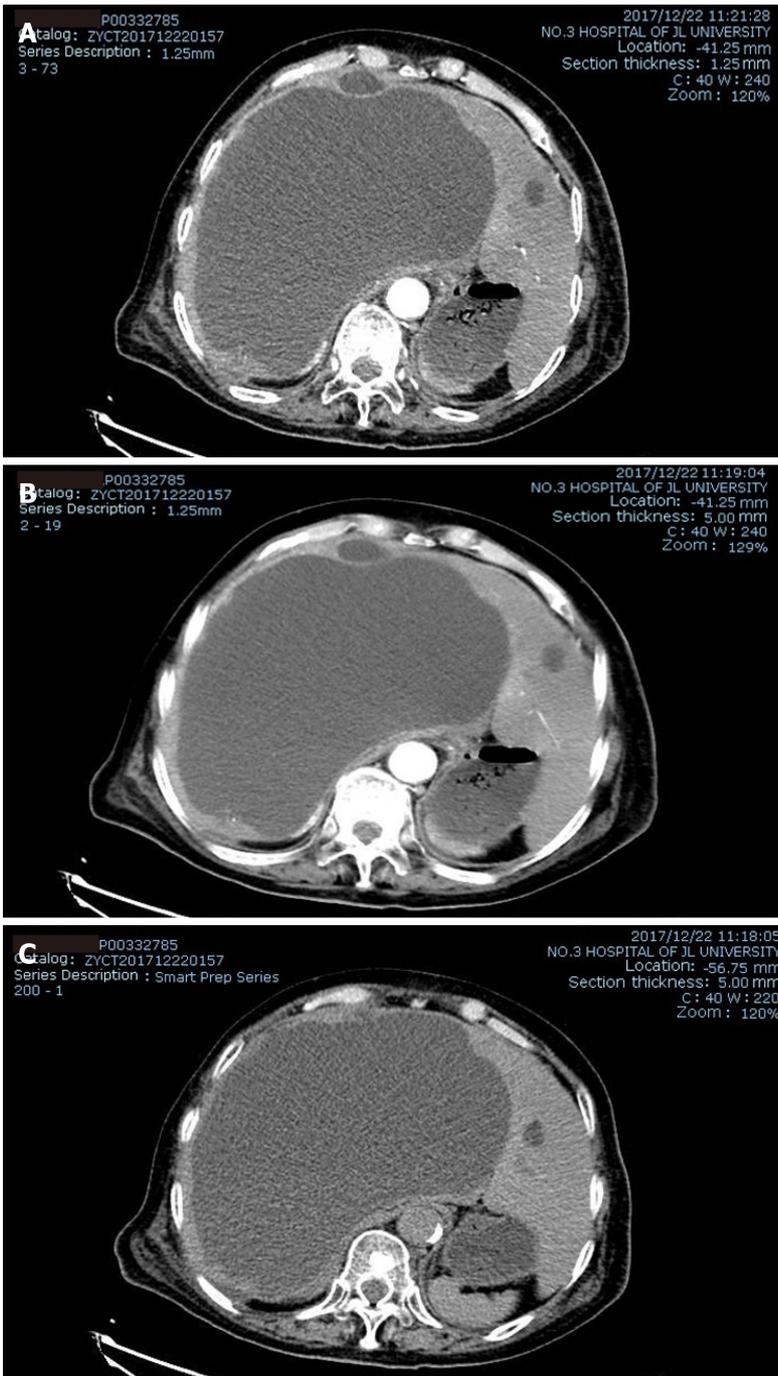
Enhanced abdominal computed tomography before treatment. A: Arterial phase; B: Venous phase; C: Balanced phase.
